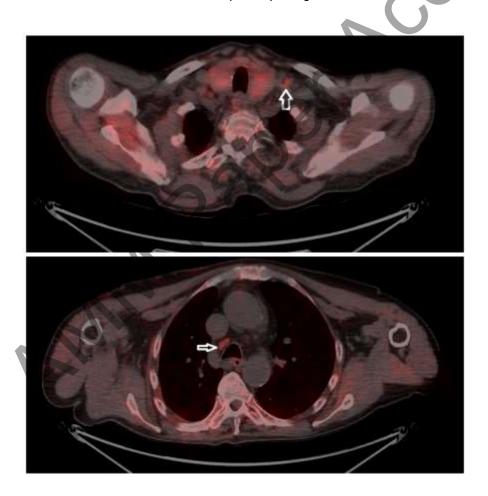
Left supraclavicular (above) (SUVmax 2.5) and right paratracheal (down) lymph nodes (SUVmax 3.0) with moderately increased FCH uptake, suspicious for metastases from pulmonary carcinoid.
